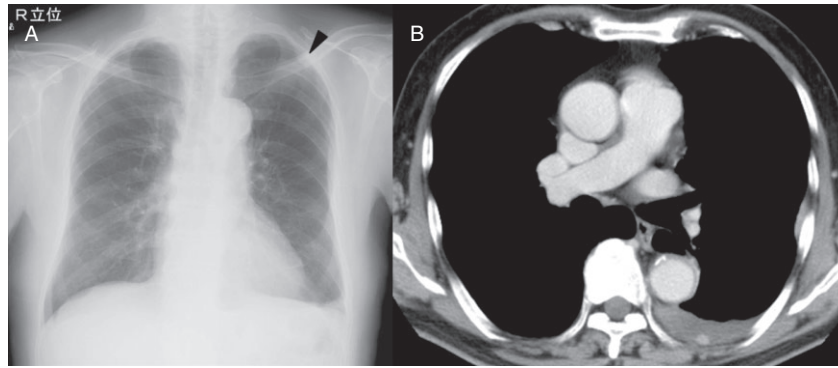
A chest X-ray revealed left costophrenic angle blunting and a well-circumscribed, pleural-based mass in the left upper hemithorax (arrow) (A). A contrast-enhanced computed tomography scan showed well-enhanced noncalcified pleural nodules and a small amount of pleural effusion. There were no pulmonary nodules and no mediastinal lymphadenopathy (B).
